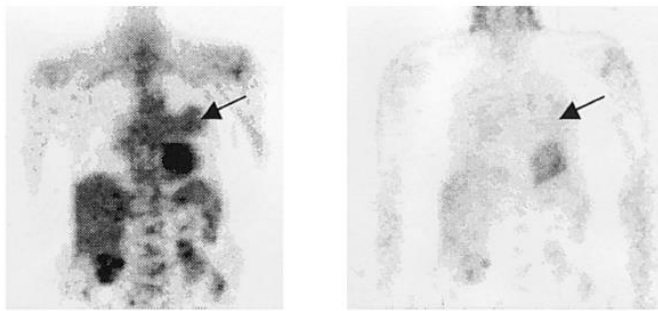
Example of FDG uptake with and without attenuation correction, respectively left and right¹⁰
